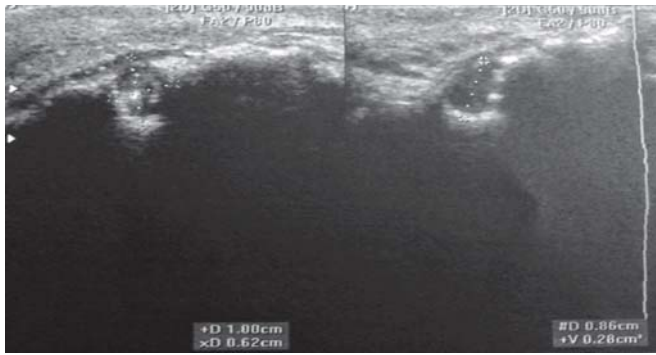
Case 1—ultrasonogram in 21, 22 region
